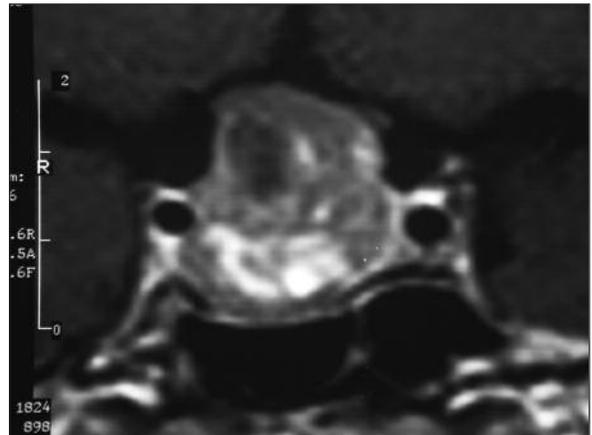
Preoperative Pituitary MRI (coronal contrast-enhanced T1 weighted image).
